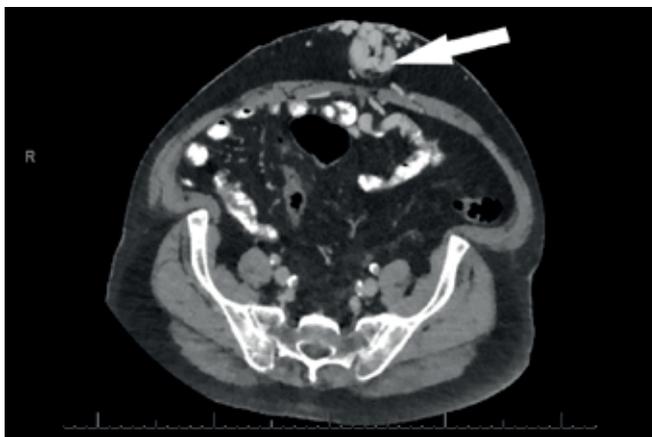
CT showing sizeable umbilical varices (white arrowhead)
